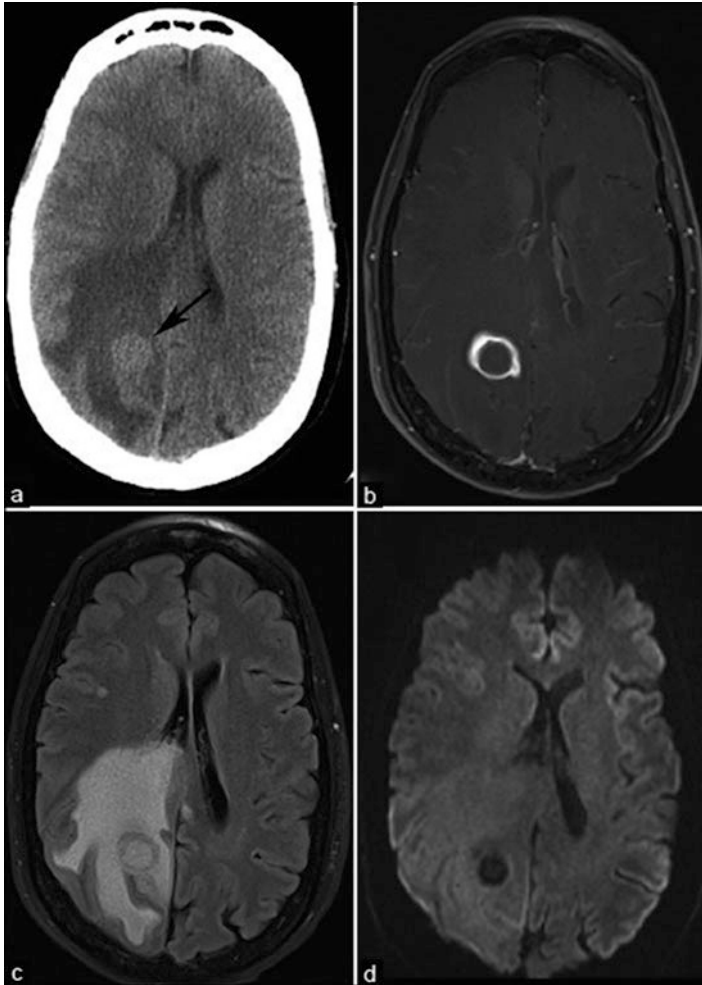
(a) CT of brain lesions. (b) Post-contrast T1 MRI. (c). FLAIR MRI. (d) DWI MRI [32]
